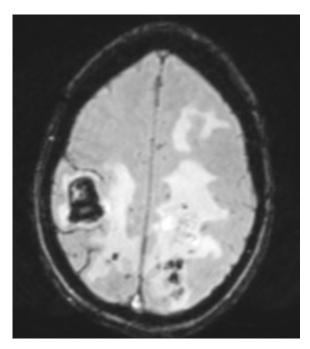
MRI Brain Axial SWI showing multiple blooming foci in both parietal lobes.
